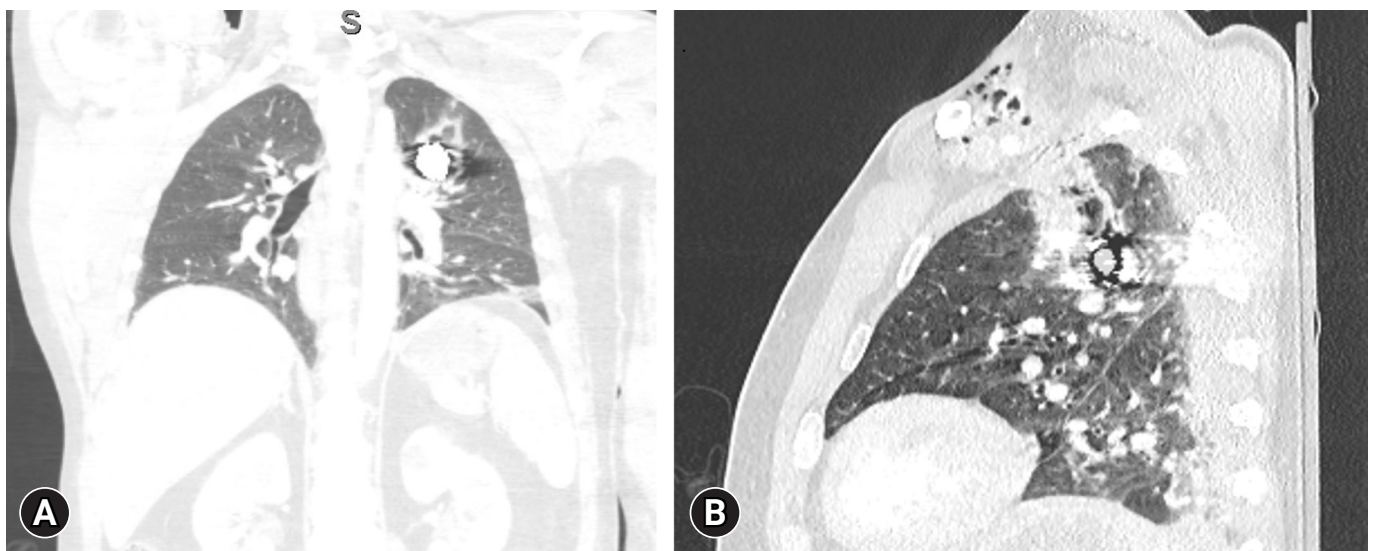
Radiographic representation of the foreign body. (A) Coronal view of the foreign body in the left chest. (B) Sagittal view of the foreign body in the left chest that demonstrates the trajectory of the ballistic through the anterior left first intercostal space, with the ballistic fragment within the left upper lobe.
